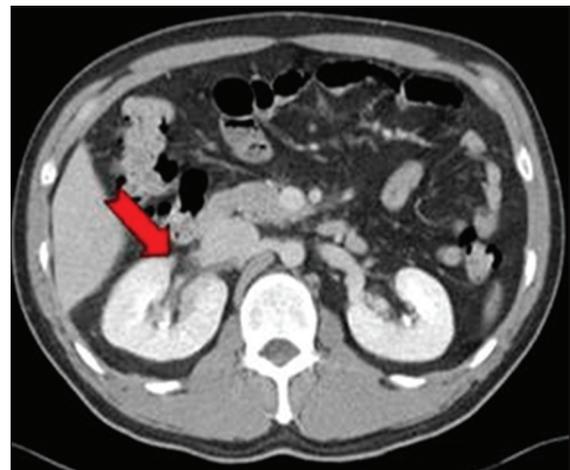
Contrast-enhanced computed tomography brain showing right renal vein thrombosis
